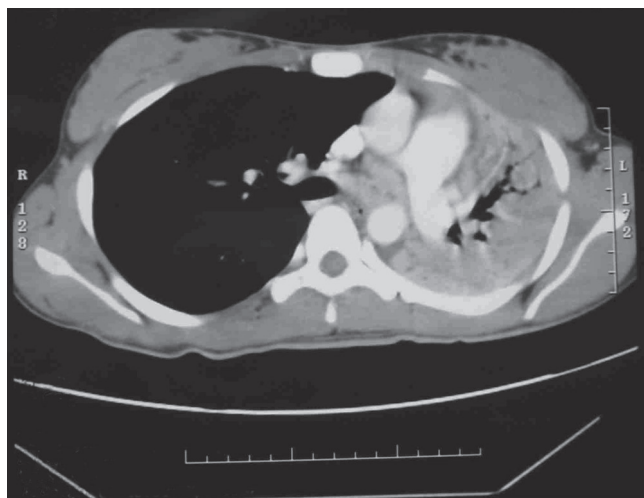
■ Inflammatory pseudotumor of the left main-stem bronchus involving the carina. The patient was treated successfully in the past with steroids; however, she has recently become afflicted with multiple pneumonias, and radiographic studies suggest that she has obstruction of the main-stem bronchus. The patient underwent left main-stem bronchial sleeve resection.
